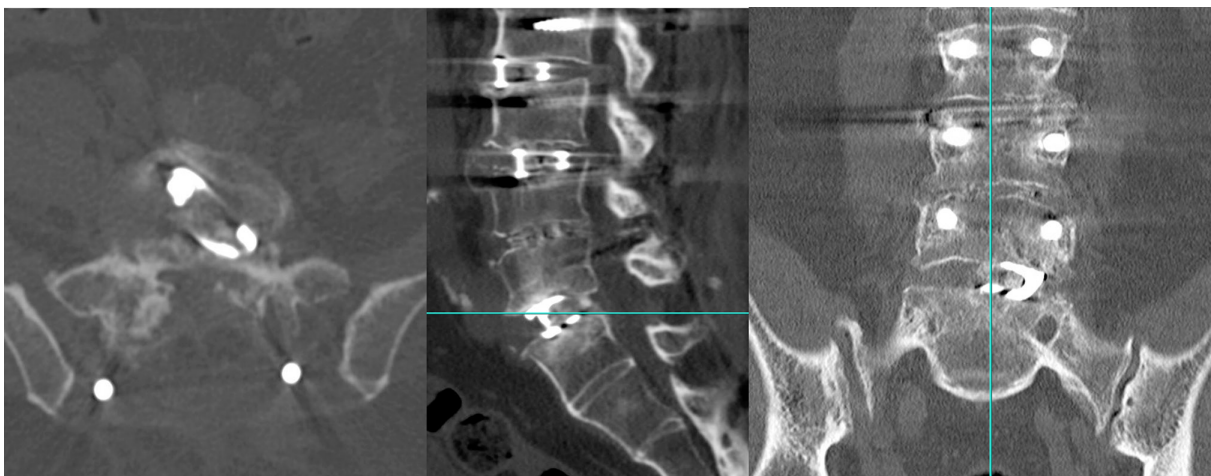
Postoperative computed tomography image at 1-year follow-up showing spinal fusion at all operated levels.
